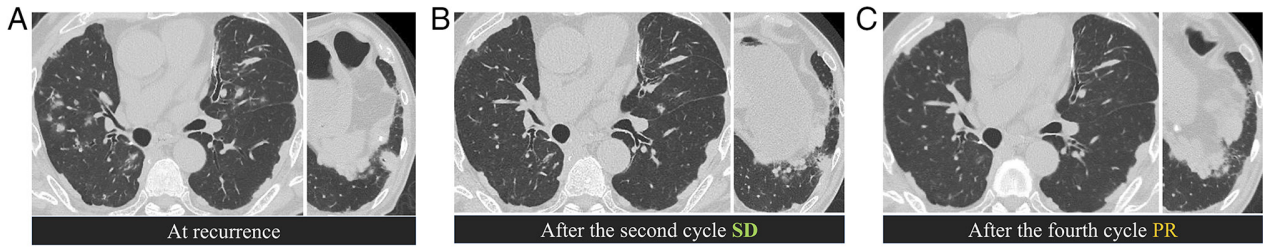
CT images for case 3. (A) CT scan at recurrence, demonstrating multiple metastatic nodules throughout both lungs. (B) CT scan after the second cycle of dual immune checkpoint inhibitors (durvalumab and tremelimumab) combined with chemotherapy (carboplatin and nab-paclitaxel), showing SD. (C) CT scan after the fourth cycle, showing partial response. CT, computed tomography; PR, partial response; SD, stable disease.
